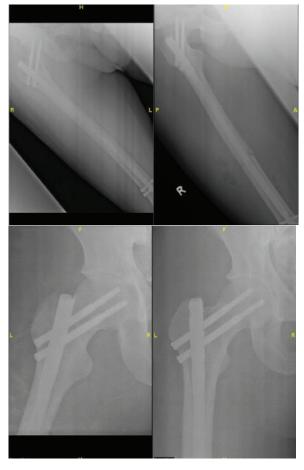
Post-operative plain radiographs of the patient. No displacement of the neck of femur fracture.
